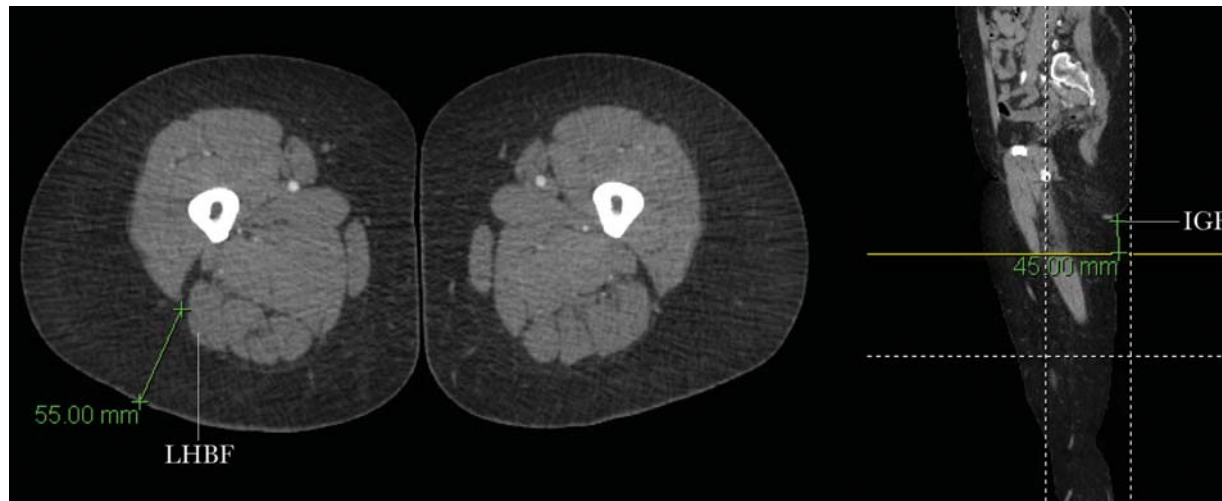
Axial (left) and sagittal (right) images of a supine-positioned computed tomography angiography scan of a patient with a subcutaneous tissue thickness of 5.5 cm at the lateral border of the long head of the biceps femoris (LHBF) at the level 4.5 cm caudal to the inferior gluteal fold (IGF). The right-sided profunda artery perforator flap had an estimated weight of 471 g and an actual weight of 440 g.
